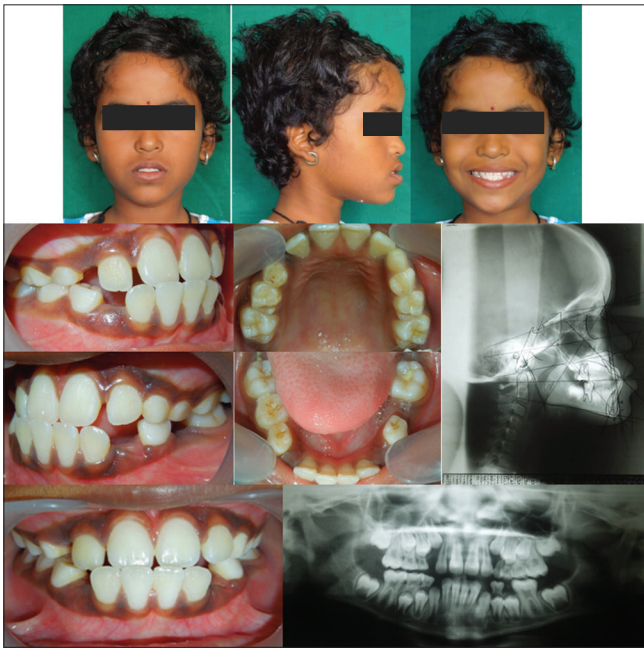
Pretreatment extraoral, intraoral photographs, orthopantomogram, and lateral cephalogram
